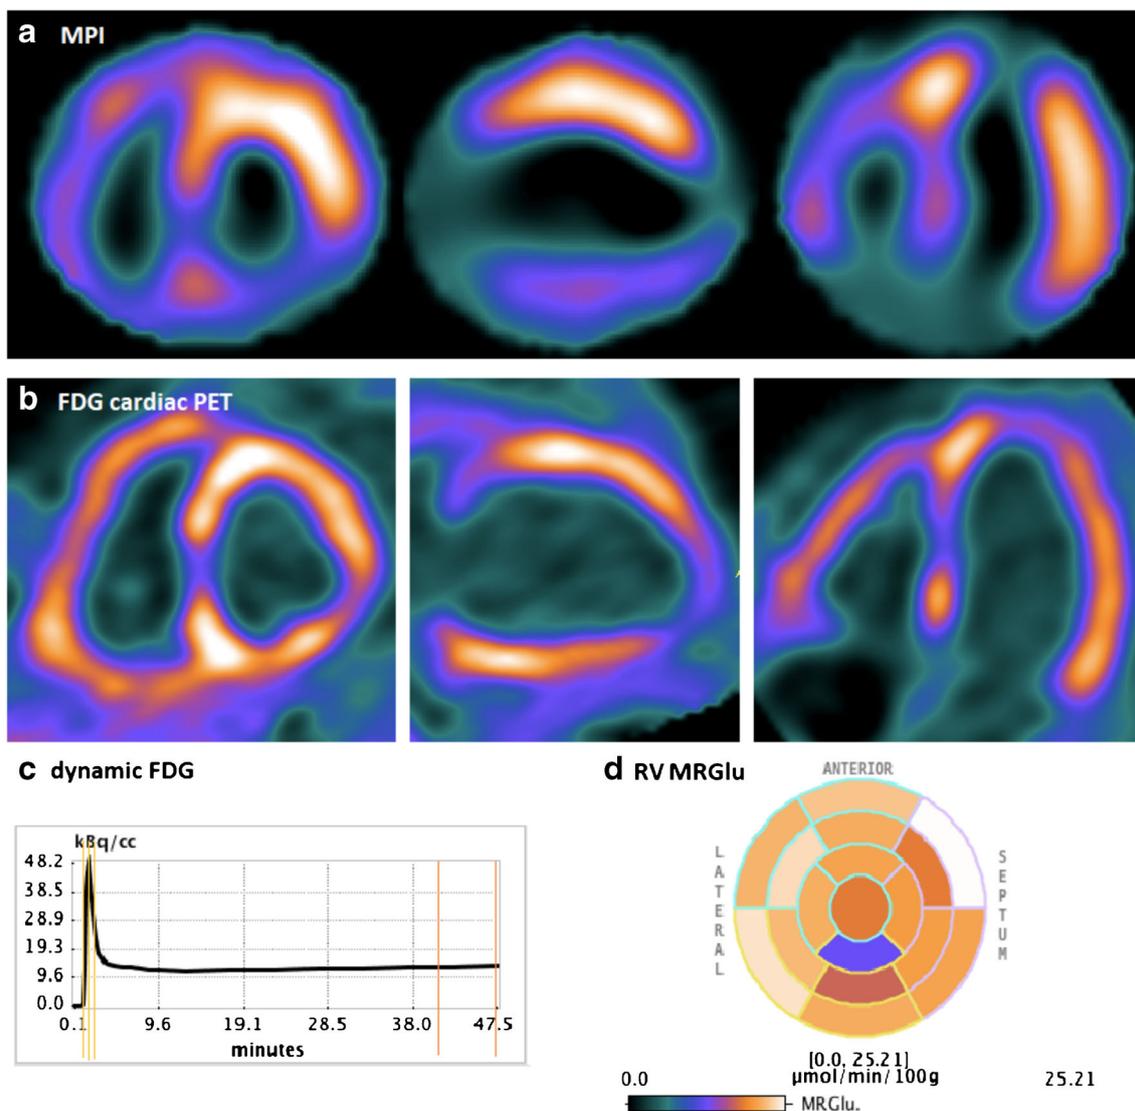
Representative images. ^{201}Tl MPI (a) and FDG PET (b) in 3-axis showed hibernating LV myocardium in the apex, inferior and inferoseptal walls, and obvious RV uptake. Dynamic FDG PET with Patlak kinetic analysis (c) of RV MRGlu (d) estimation were displayed
